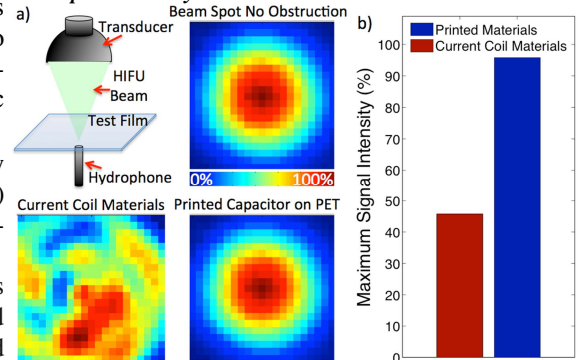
(a) Setup and acoustic power distribution from transducer as seen by a hydrophone over a 20x20 mm² area. (b) Maximum signal intensity of ultrasonic signal transmitted through printed and conventional coil materials.
